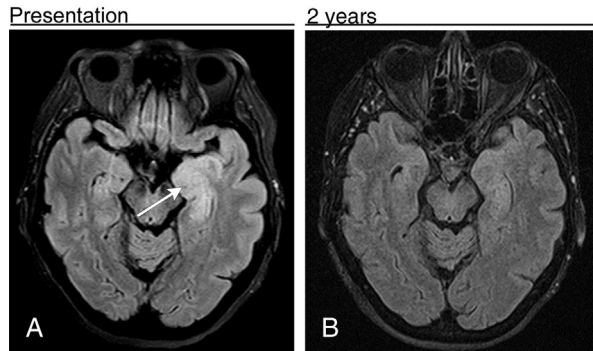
Transient temporal lobe postictal changes. Adult female with history of metastatic breast and endometrial carcinoma presenting with seizures. Nonenhancing FLAIR hyperintense signal abnormality is seen within the medial left temporal lobe at the time of presentation (A; arrow). Complete interval resolution of left temporal lobe signal abnormality is noted 2 years later (B). In light of resolution of imaging findings, as well as the documented normal EEG, normal spinal fluid, and normal paraneoplastic screen, these findings most likely represent resolution of transient postictal edema.
